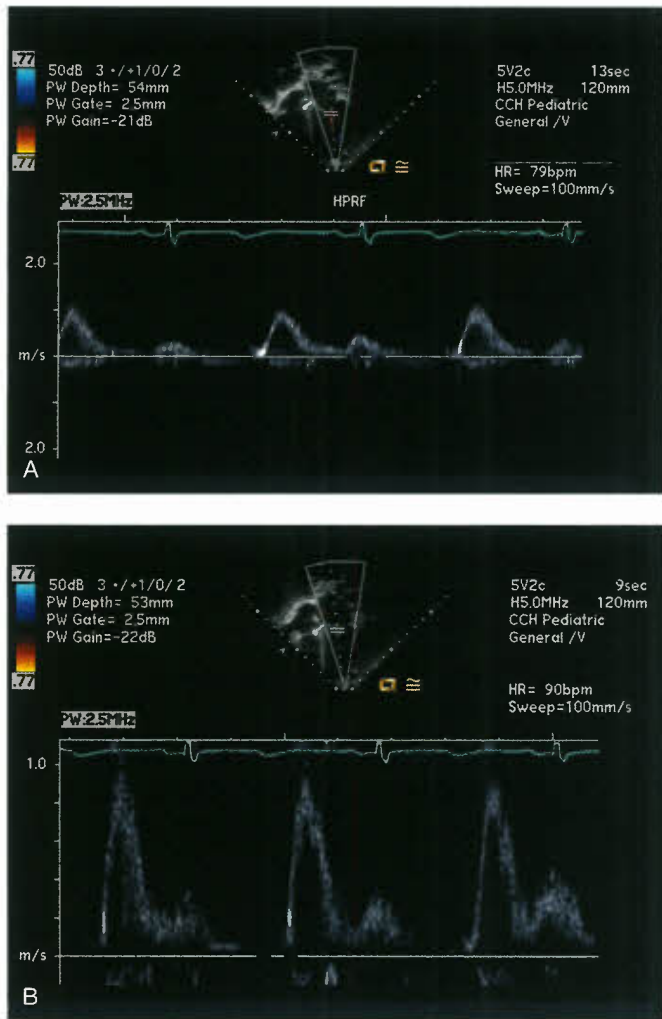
Mitral valve Doppler spectral profile recorded with (A) inappropriate and (B) appropriate scale and baseline shift. It is important to fill as much of the Doppler display area, thereby enlarging the Doppler spectral profile as much as possible thus minimizing error in measurement (B).
